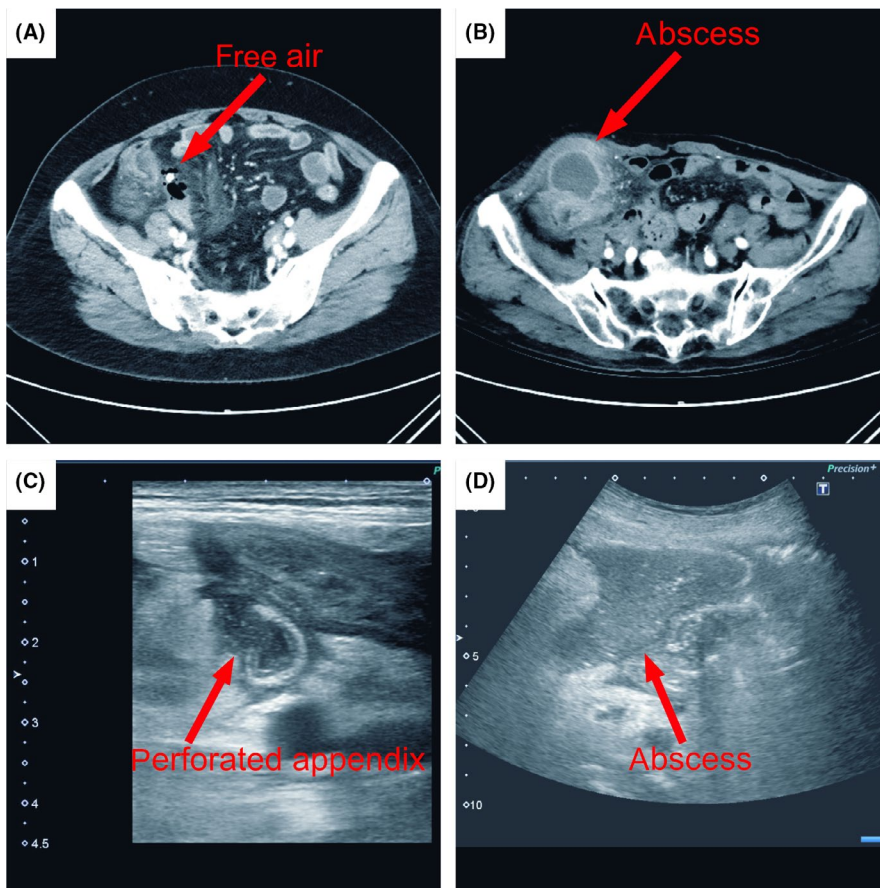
Definition of severe complicated appendicitis. A, Appendicitis accompanied by free air and/or (B) abscess based on computed tomography and (C) deficiency of the appendix wall and/or (D) a peri-appendiceal abscess based on ultrasound
